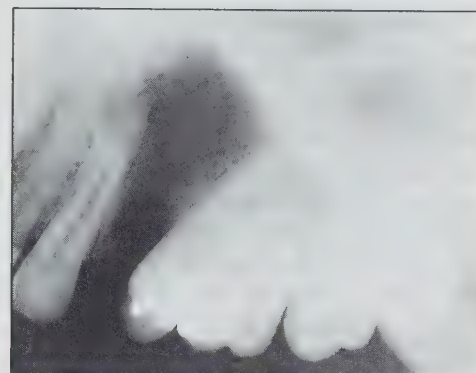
Occlusal radiograph of a large, chronically inflamed, residual radicular cyst, only the anterior portion of which is corticated. Tooth 2.4 had been extracted 10 years previously and the patient had been experiencing recurrent draining sinuses for approximately two years.
